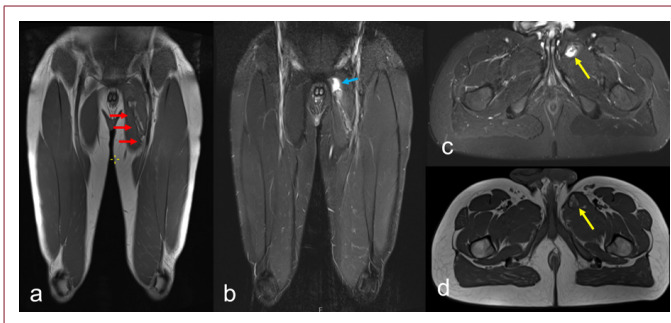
Magnetic resonance imaging (MRI) of the pelvis and proximal thighs showing findings consistent with complete adductor longus rupture and associated myositis ossificans. (a) Coronal T1-weighted image demonstrating discontinuity and retraction of the adductor longus muscle fibers (red arrows). (b) Coronal fat-suppressed T2-weighted image showing hyperintense edema and fluid at the proximal rupture site with a hypointense ossified lesion within the muscle belly (blue arrow). (c) Axial fat-suppressed T2-weighted image revealing a well-demarcated ossified mass within the adductor longus muscle (yellow arrow). (d) Axial T1-weighted image showing mature ossification with signal intensity similar to cortical bone (yellow arrow).
